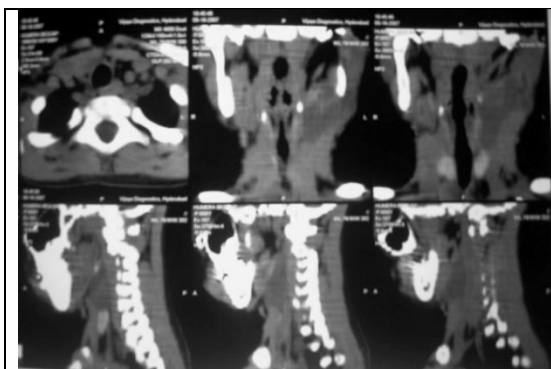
CT scan of neck on sagittal and coronal reconstruction showing soft tissue lesion in upper part of left side of neck close to the carotid sheath
